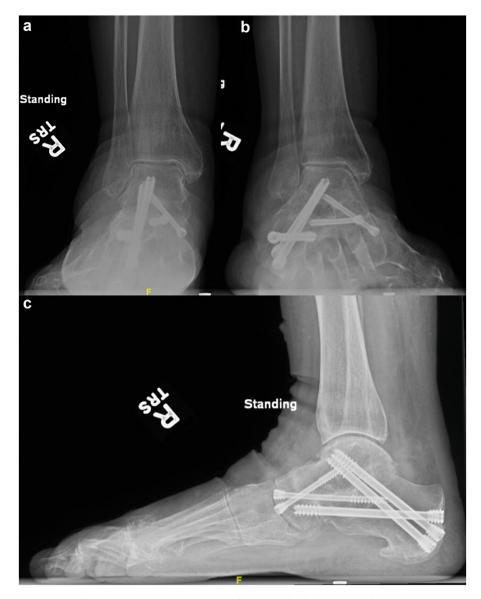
Six-month status post right ankle triple arthrodesis standing radiographs.
